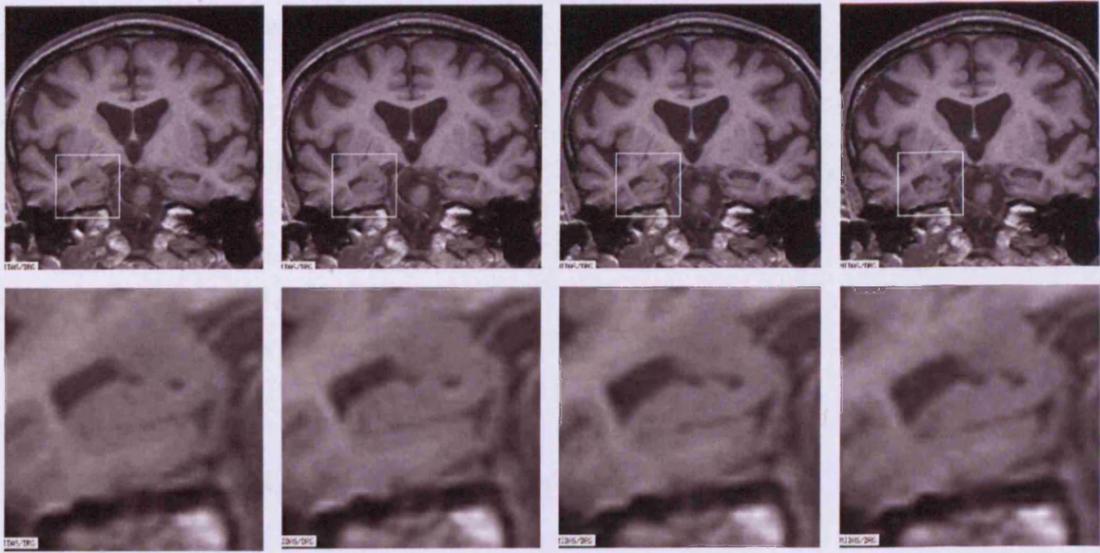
MRI showing coronal sections of the brain at baseline, nine months, two and three years (from left to right)
